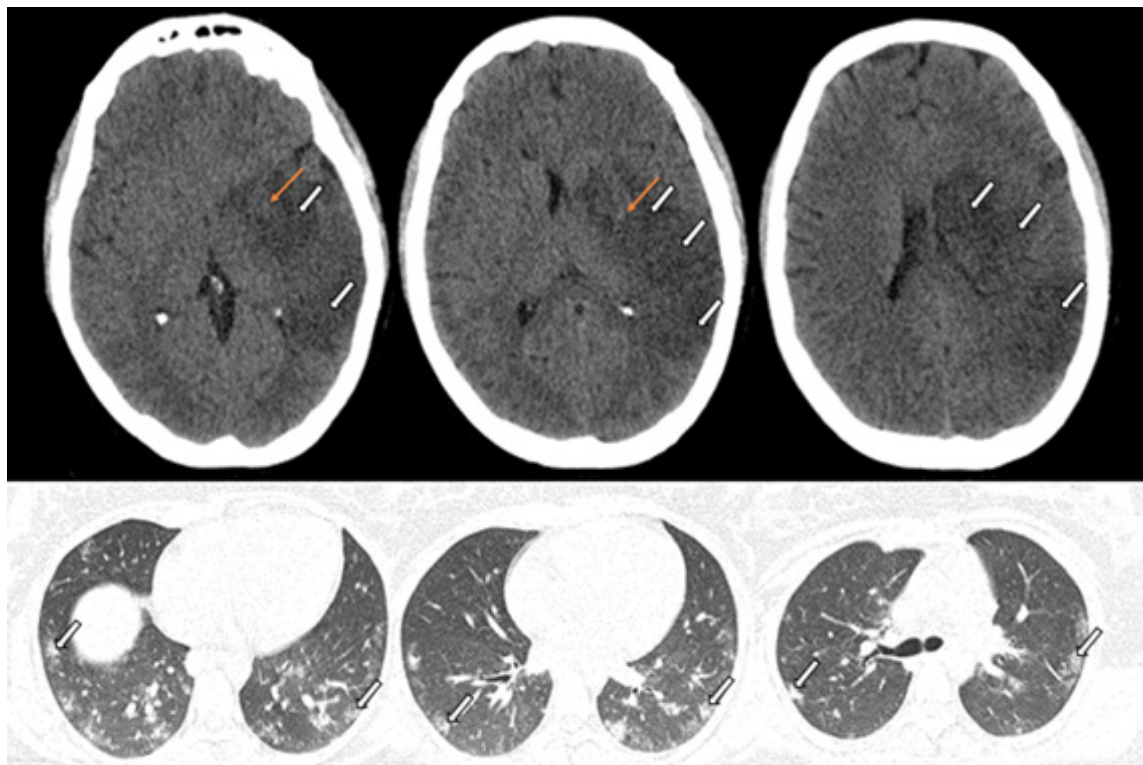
Unenhanced brain CT scan (top row) demonstrates hypodense areas in MCA territory, including basal ganglia, suggestive of a subacute stroke with subtle hyperdense foci, indicating hemorrhage. Chest CT scan (bottom row) shows bilateral patchy peripheral ground-glass opacities associated with consolidation foci, typical CT imaging features for COVID-19<sup>1</sup>.
